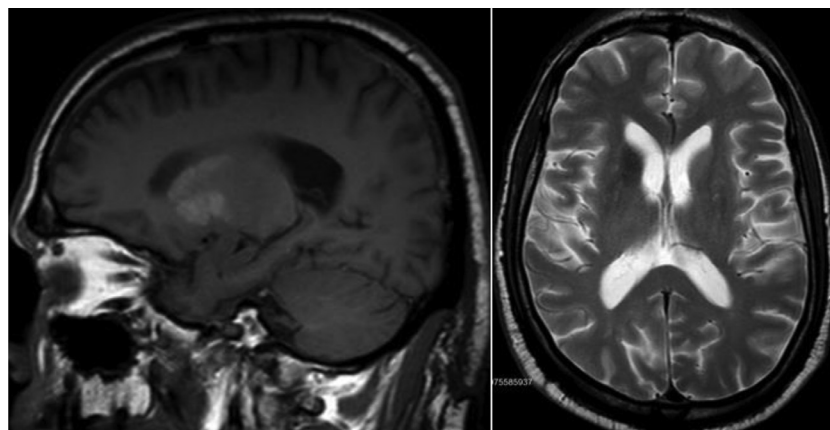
T1 and T2 sequence of brain MRI respectively: demonstrating high signal intensity in T1 and low T2 signal intensity and changes at the region of the right basal ganglia.
